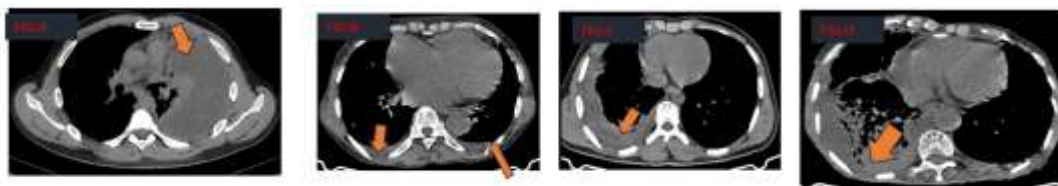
6: A,B,C,D showing different types of PE on CT
